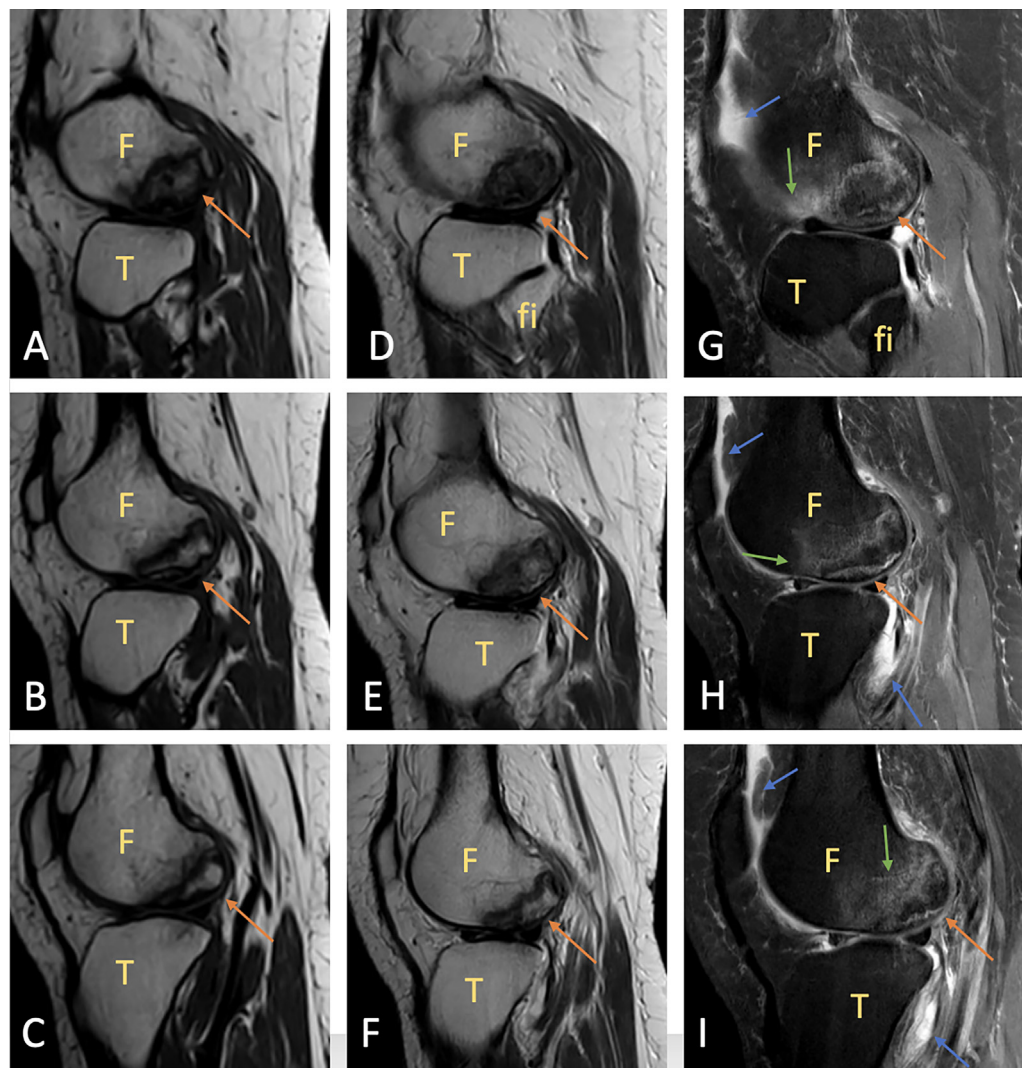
Sequential Magnetic Resonance Imaging of the knee joint sagittal sections T1 weighted imaging (A, B, C), T2 weighted imaging (D, E, F), and proton density fat-suppressed imaging (G, H, I) sequences showing an altered signal intensity area in the lateral femoral condyle giving an appearance of a geographical region showing rim sign and double line sign with surrounding bone marrow OEDEMA (green arrows), minimal joint effusion (blue arrows) and normal appearance of the articular cartilage suggesting avascular necrosis of lateral femoral condyle (orange arrows). F, femur; fi, fibula; T, tibia.
